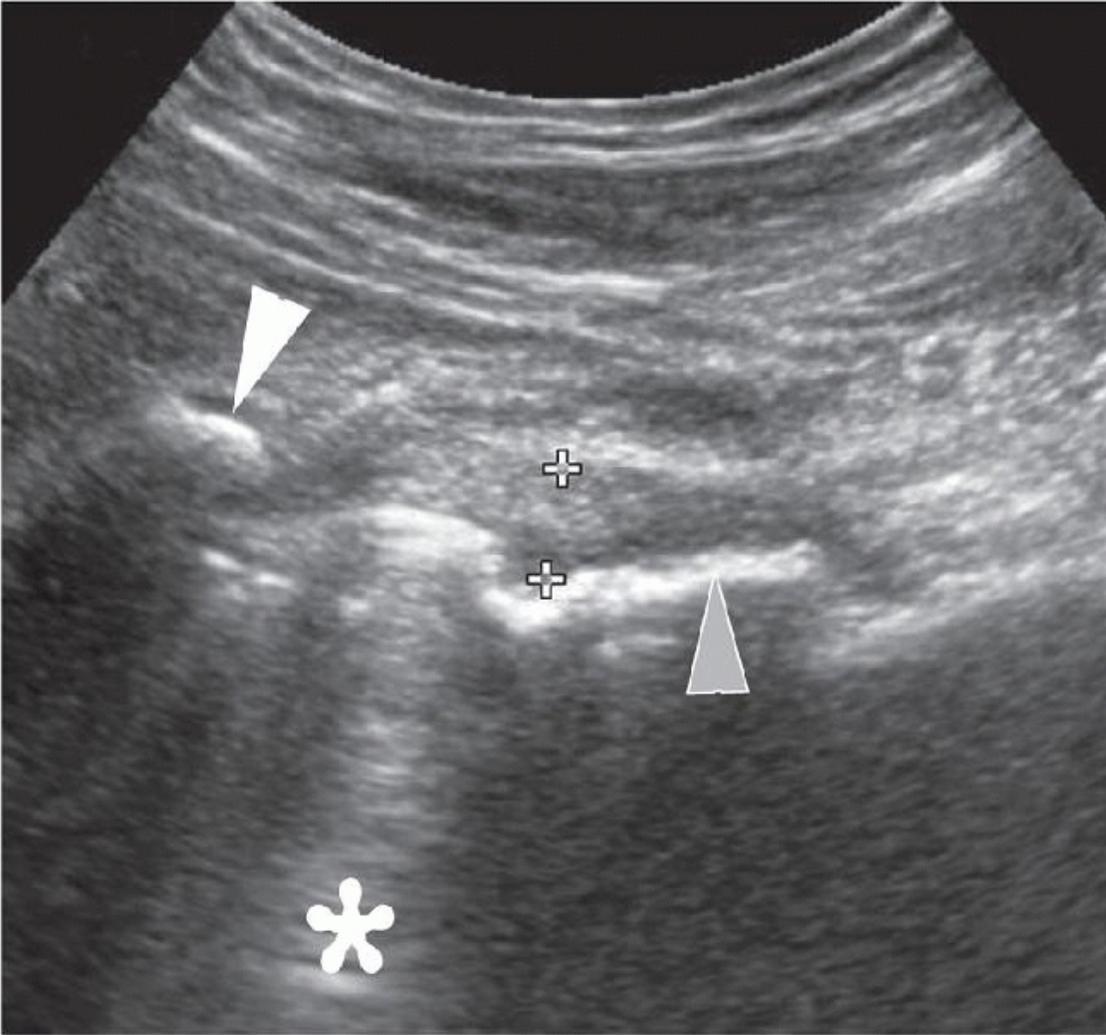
Normal sonographic appearances of a metallic hip. Longitudinal sonogram shows metal-on-metal resurfaced hip with the typical hyperechoic margin at the acetabulum (white arrowhead), femoral neck (gray arrowhead), and significant reverberation artifact. Calipers measure the capsule that shows typical thickening postsurgery.
